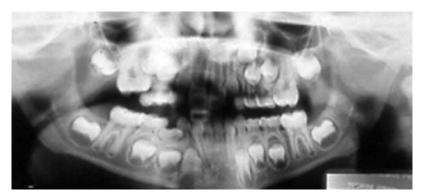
Panoramic radiograph at treatment beginning
